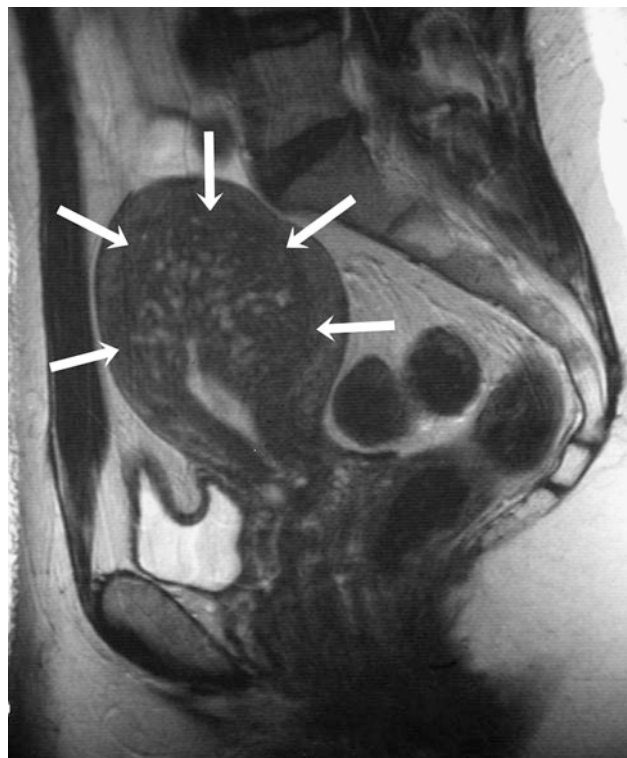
MRI imaging for pre-procedure evaluation. Sagittal T2-weighted MR image of the pelvis demonstrating adenomyosis (arrows) in a patient previously diagnosed as having fibroids based on an ultrasound examination
